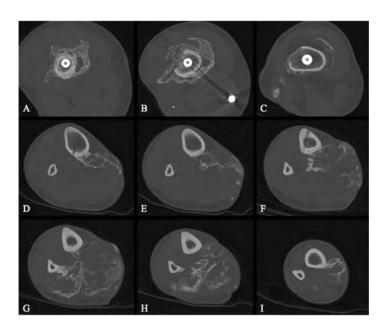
Axial CT scan, moving from proximal to distal, of case 2, demonstrating encasement of the deep artery and vein in the thigh (A-C) and the posterior tibial and peroneal arteries as well as the tibial nerve in the leg (D-I).
